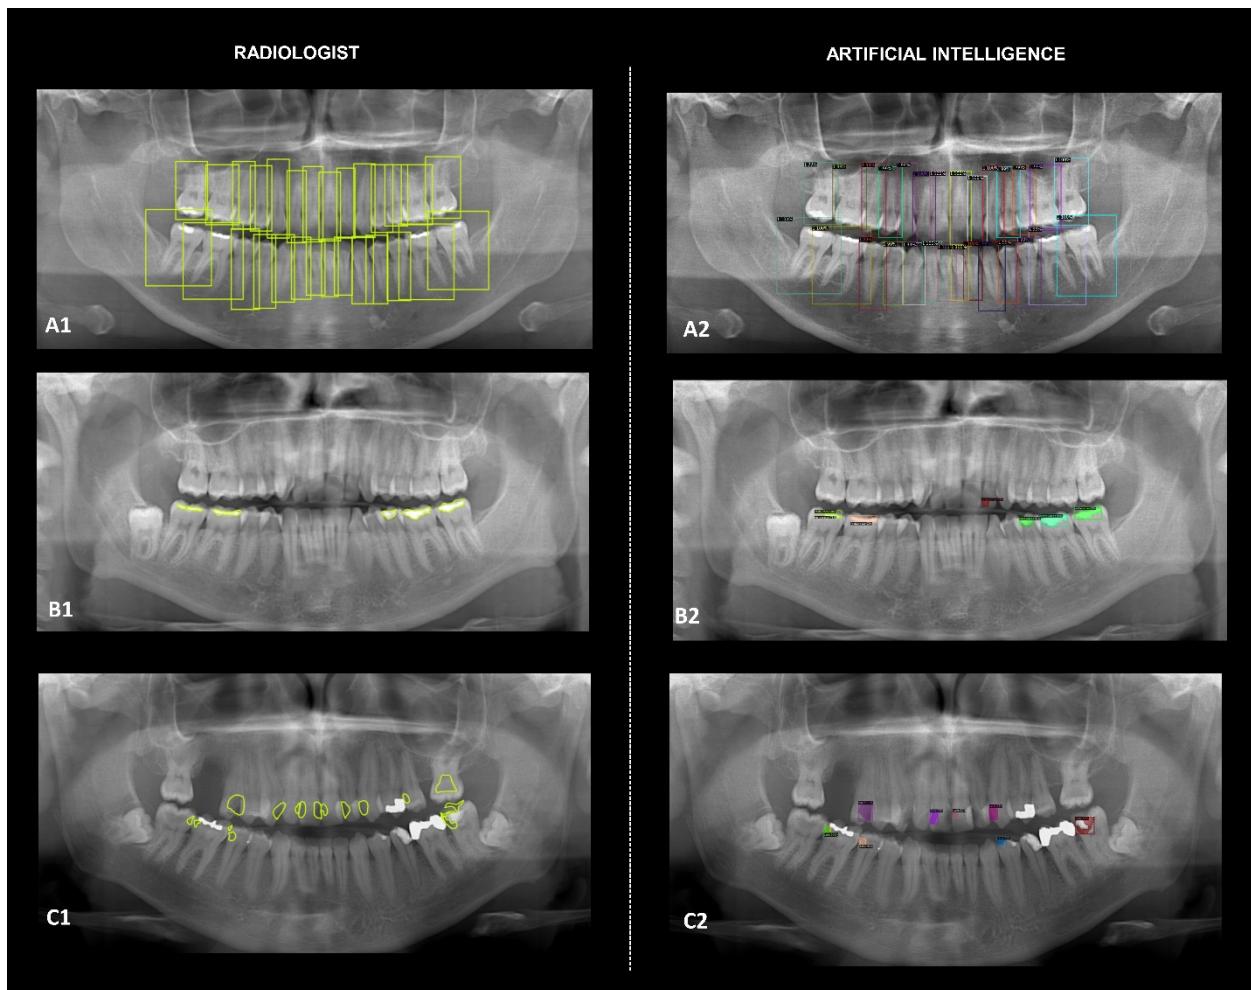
Examples of detection of tooth (bounding box) (A), segmentation of dental restorations (B) and carious lesions (C) on panoramic radiographs. (1) Labeling performed by the radiologist; (2) labeling performed by AI algorithm (Faster and Mask R-CNN adapted).
